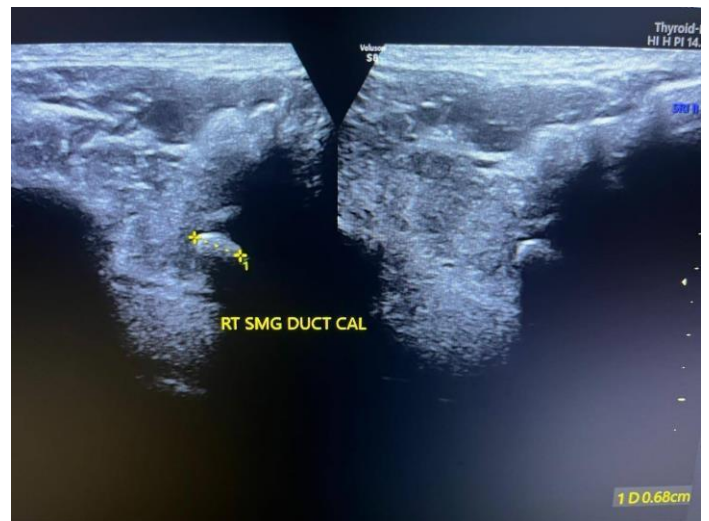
Ultrasonography picture of calculi at distal end of Wharton's duct.
